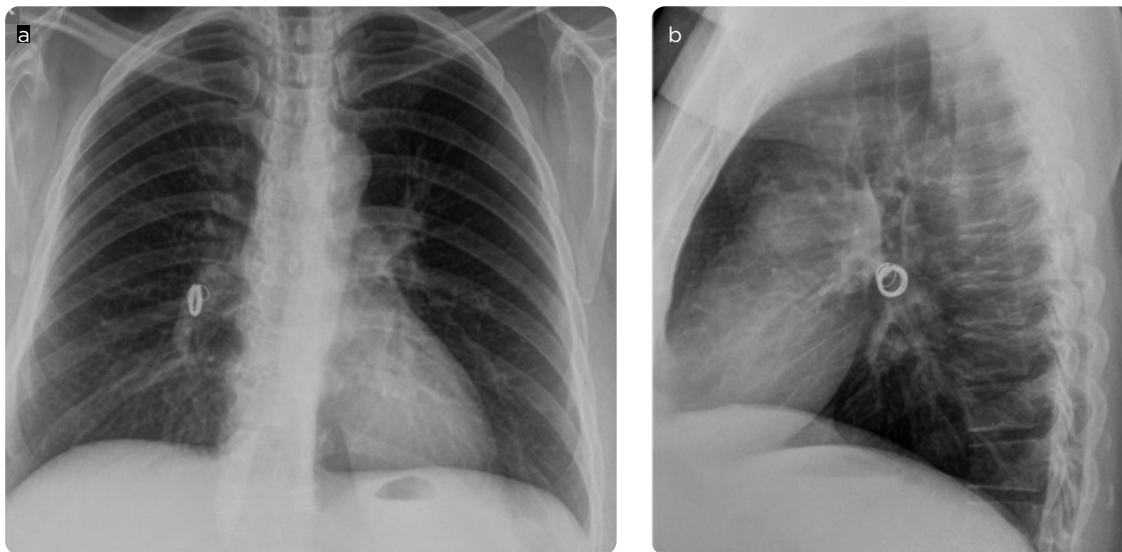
Posteroanterior and lateral chest X-ray: radio-opaque spiral image projected in the right pulmonary hilum, corresponding to migration of the embolization material.
